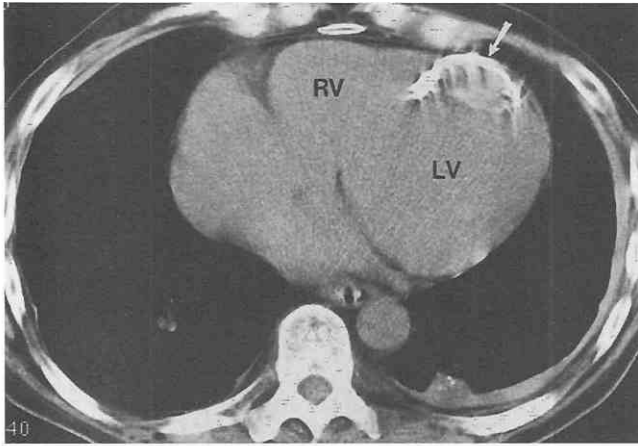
Calcified left ventricular aneurysm. CT shows a thin, curvilinear calcification (*arrow*) in the left ventricular apex, consistent with left ventricular aneurysm resulting from a prior infarction. LV, left ventricle; RV, right ventricle.
